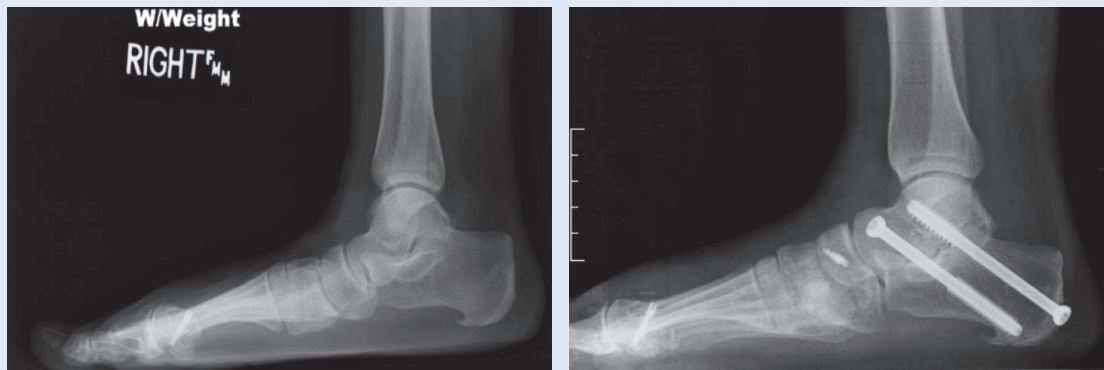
The pre and post operative radiographs of an obese female patient with a rupture of the PTT and a rupture of the spring ligament. This was treated with a subtalar arthrodesis, transfer of the FDL, and a spring ligament reconstruction.
